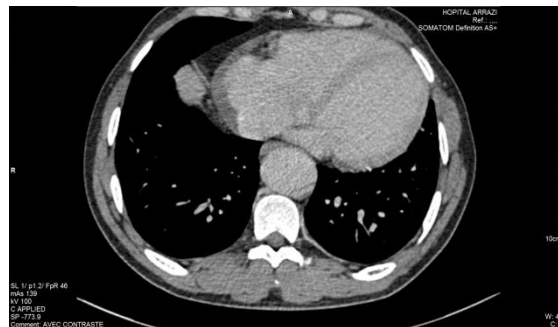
CT scan showing descending aortic dissection
